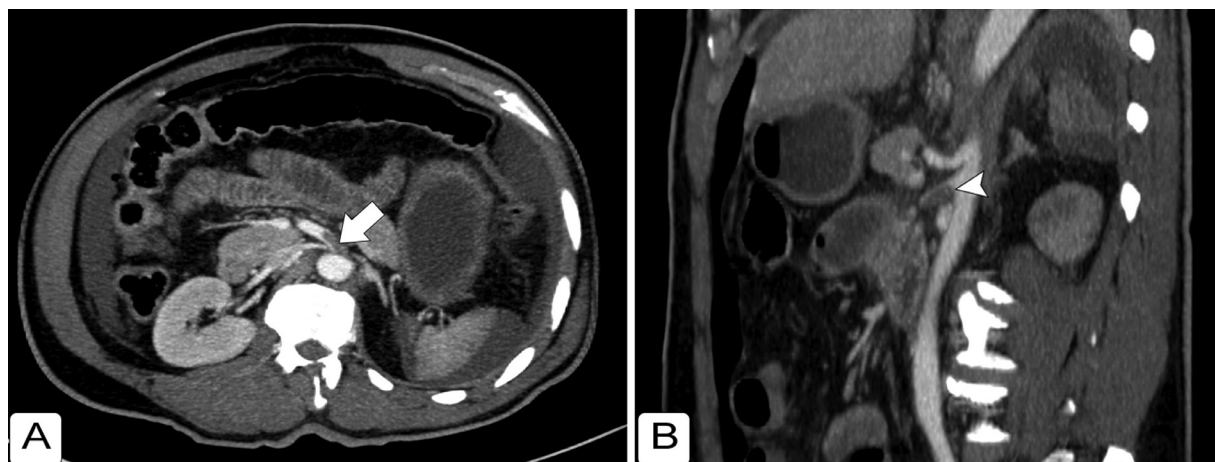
Contrast enhanced CT of the abdomen in axial (A) and sagittal (B) section showing filling defect in the superior mesenteric artery.
